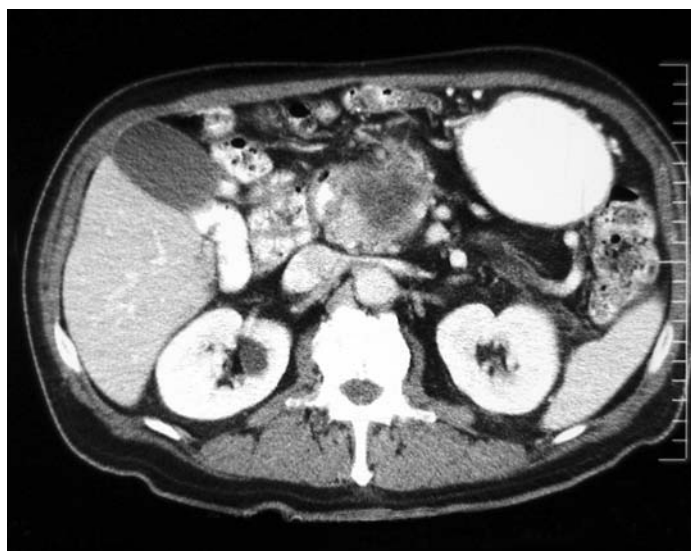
CT angiography performed to evaluate vascular invasion in a 58-year-old patient with a pancreatic mass demonstrates nearly complete encasement of the superior mesenteric vein. The superior mesenteric artery is not involved with the mass.
